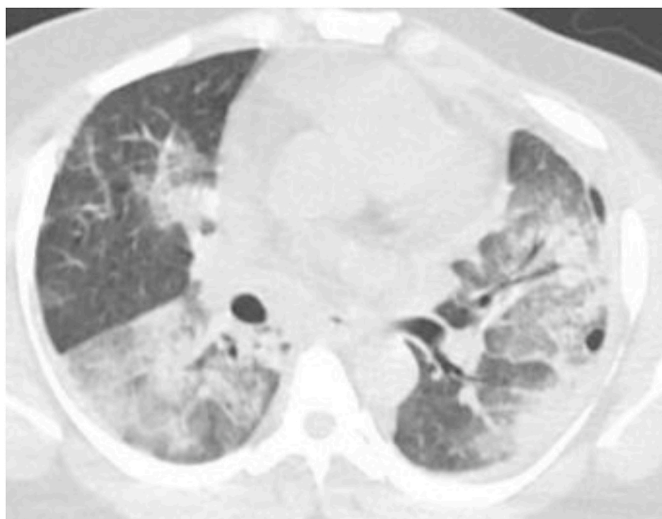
Chest tomography one month later. CT Chest on month later shows interval improvement in the right lower lobe consolidations but more extensive ground glass in the left lower lobe with occasional subpleural cysts.
